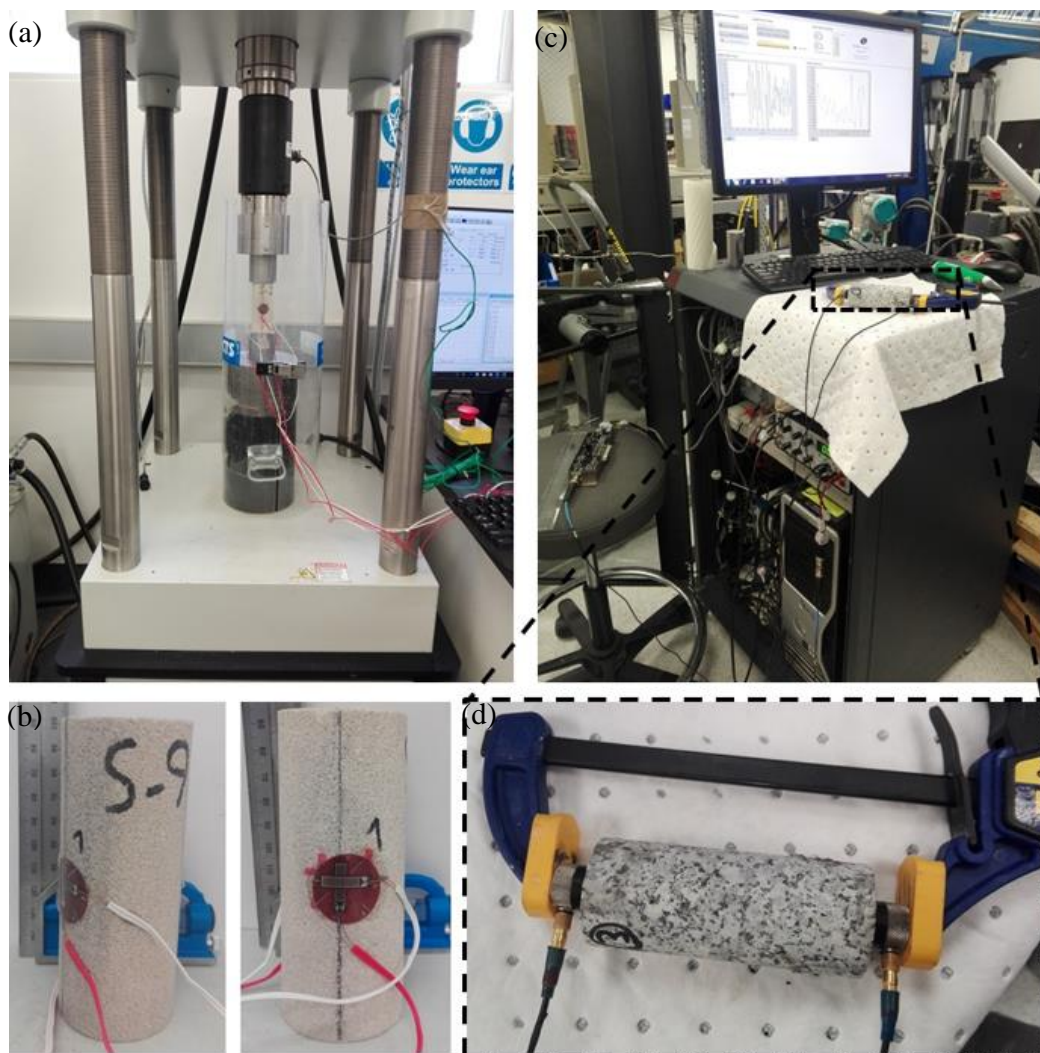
Testing equipment: (a) UCT-1000 uniaxial compression test frame, (b) two rosette strain gauges attached on two sides of the sample, (c) ultrasonic measurement system, and (d) ultrasonic transducers during measurement.
